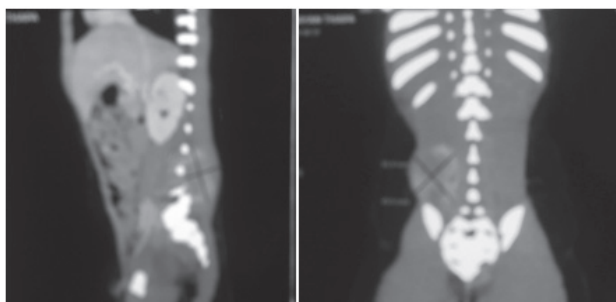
2a & b. CT Scan of whole spine showing isodense paravertebral mass on right lumbosacral region without involvement of spines.
